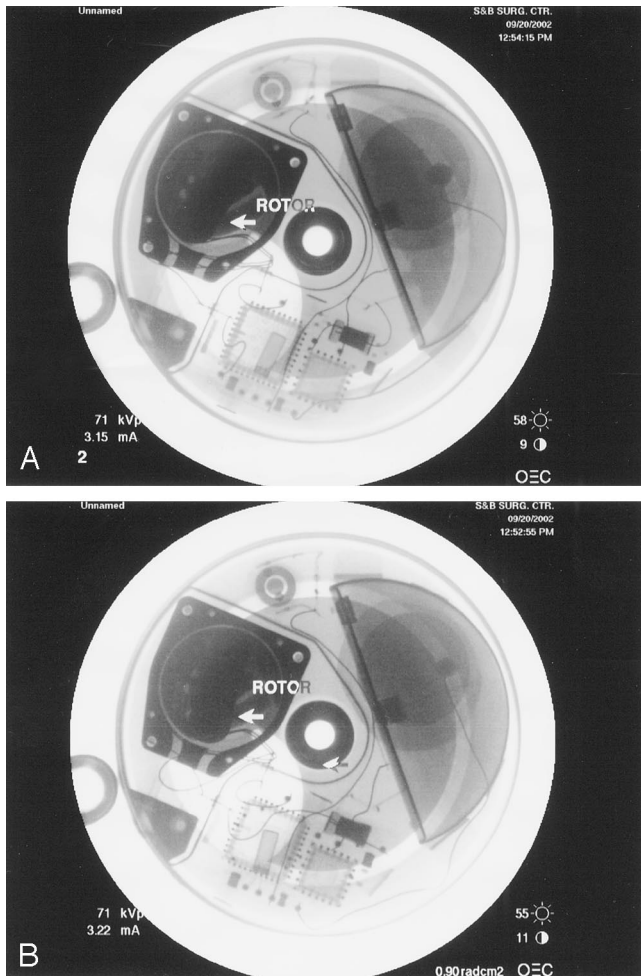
Radiograph of implanted pain pump. A, Labeled rotor before rotation. B, Rotor after rotation. Notice the change in the movement of the rotor indication that the pump is turning.
